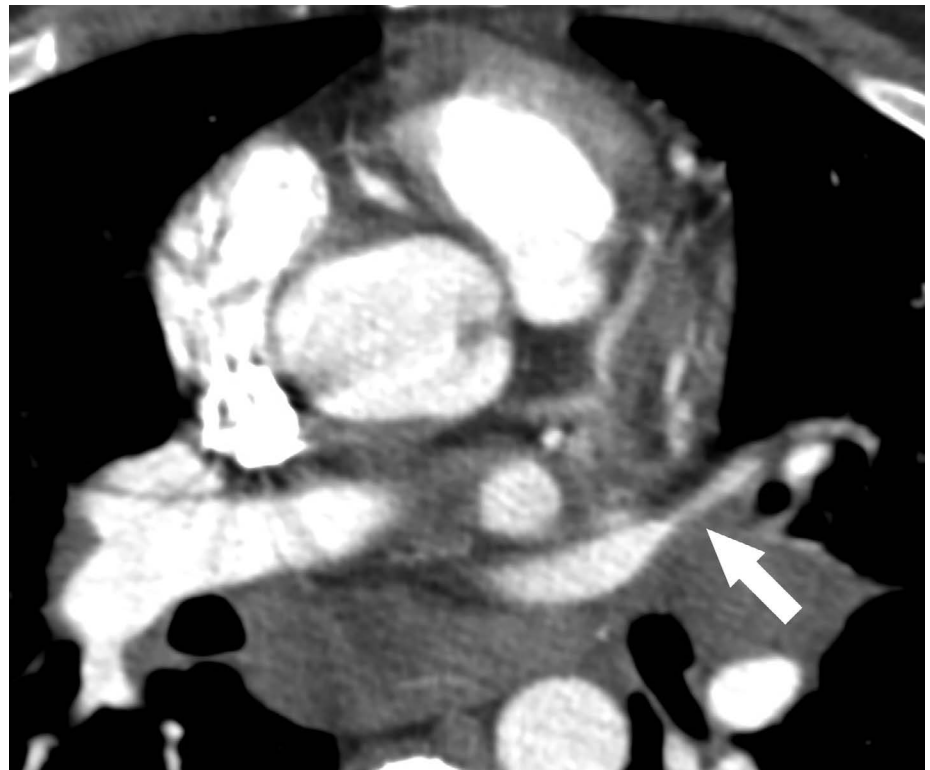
Contrast-enhanced chest computed tomography image shows stenosis of the left superior pulmonary vein (arrow) and left hilar and subcarinal lymphadenopathy.
